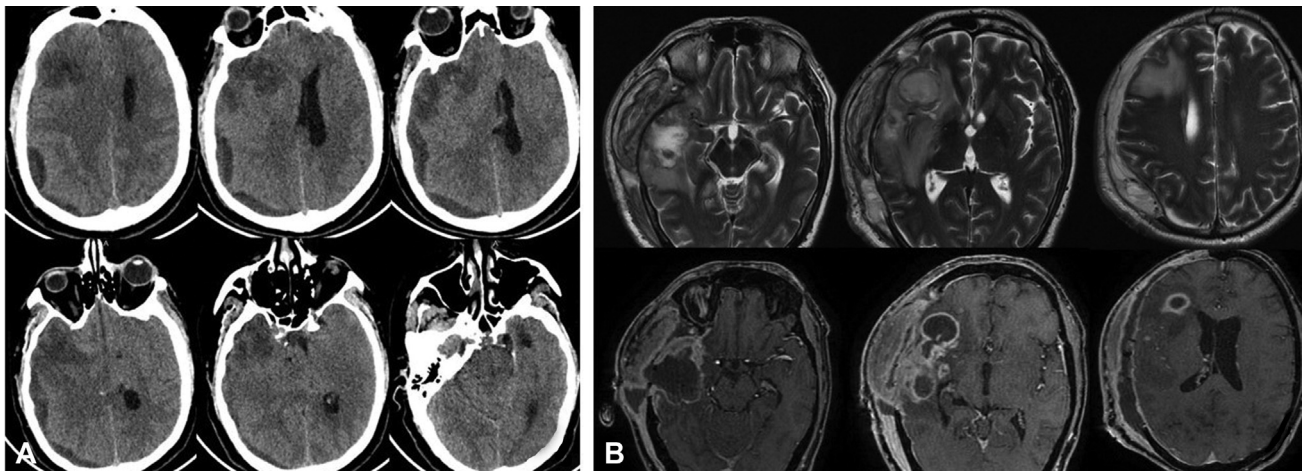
(A) Preoperative axial noncontrast computed tomography images showing right fronto-temporo-parietal extra-axial hypodensity, with right temporal lobe ill-defined hypodensity with significant mass effect. (B) Magnetic resonance imaging of brain. Top row: Axial T2 sections showing absence of bone in right fronto-temporo-parietal region along with iso- to hyper-intense lesions in right frontal area, with heterogeneous changes in right temporal lobe with surrounding edema. Bottom row: Axial postcontrast T1 images suggestive of multiple ring-enhancing lesions involving right frontal and temporal areas with central nonenhancing areas and enhancement in temporalis muscle and subgaleal region.
